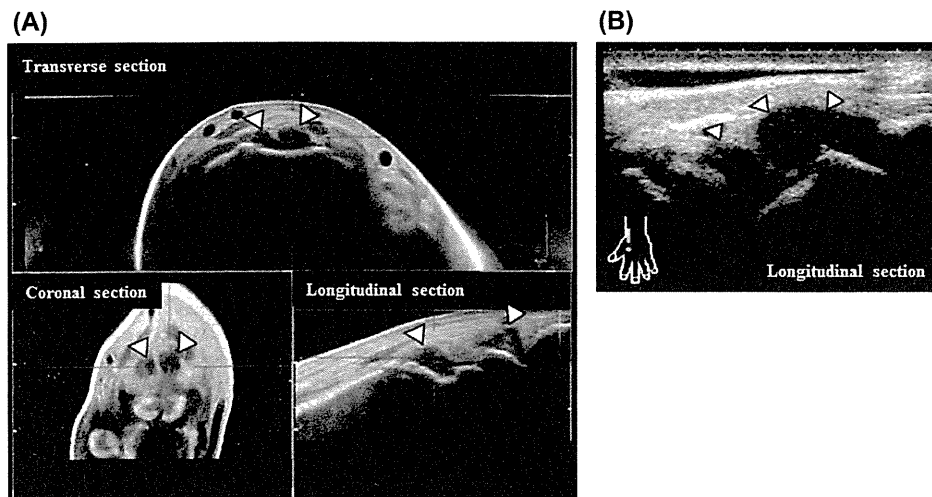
Synovial hypertrophy of an RA patient's wrist joint. The synovium is thickened in the radiocarpal and intercarpal joints (arrowhead). (A) ABVS. (B) Conventional ultrasonography.
